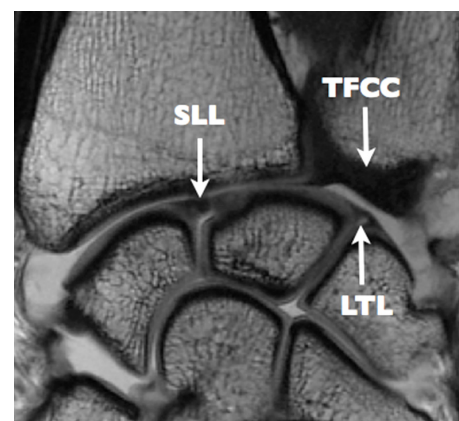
MR arthrography of the wrist. T1-weighted sequence in a coronal plane shows scapholunate ligament (SLL), lunotriquetral (LTL) and articular disk of the triangular fibrocartilage complex (TFCC).
